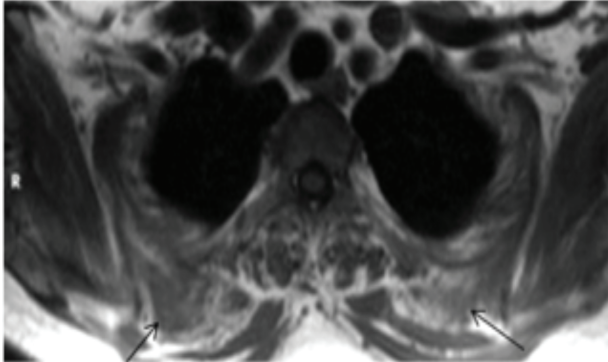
a : ultrasound examination of the right scapular area shows the oval soft tissue mass located behind the ribs. Its echogenicity is slightly heterogeneous, with hyperechoics streaks along the great axis of the mass. b: Axial unenhanced computed tomographic (CT) scan demonstrated a right sub scapular ill-defined, non heterogeneous soft tissue mass bordered by serratus anterior dorsi and ribs latissimus c : Axial MRI: unenhanced T1-weighted image demonstrates the presence of different tissue components within the lesion: alternated plan of fat-like and fibrous-like tissue getting the lesion a multi layered pattern.
